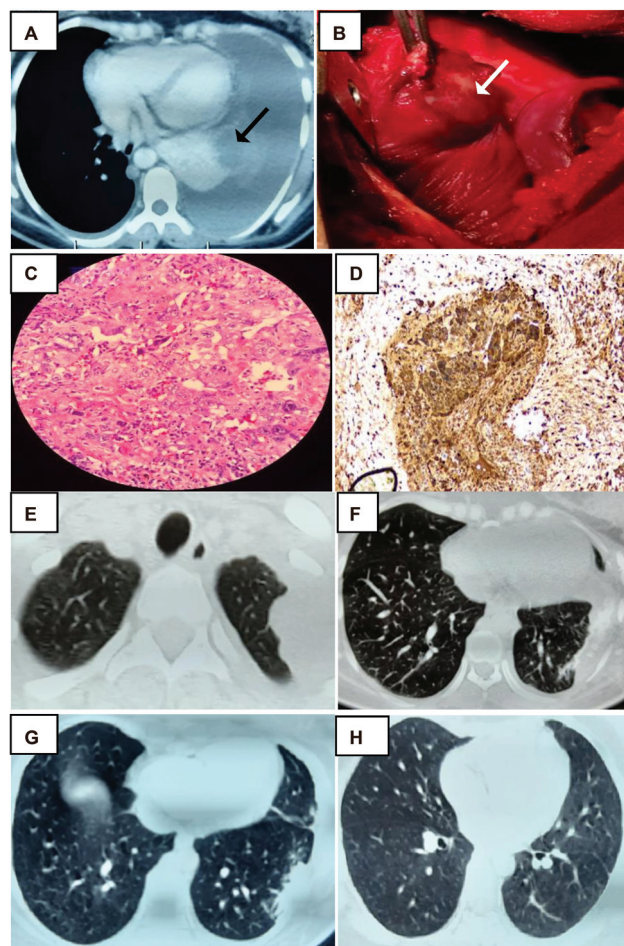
CT thorax showing hemothorax, lesion in left lower lobe (black arrow). (A). Intraoperative lung mass (white arrow). (B) Syncytiotrophoblast surrounded by cytotrophoblast in biopsy and IHC positive for β HCG. (C and D) Post-surgery CT thorax - residual lesions in the left upper and lower lobe. (E and F) CT thorax post treatment with soft calcified nodule over left upper lobe and normal lower lobe (G and H).
